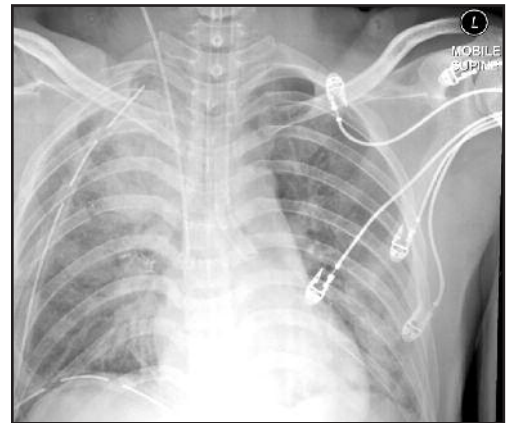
Chest radiograph which revealed a completely collapsed right lung.
